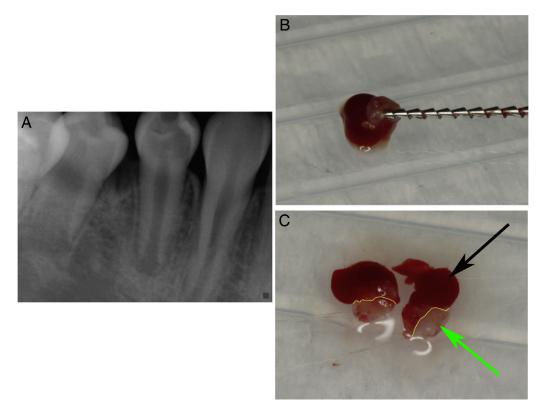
Case report radiograph and clinical photographs. (*A*) A periapical radiograph of tooth #28. (*B*) Periapical tissue was engaged to a H-file after removal from the root canal of tooth #28. (*C*) Tissue was immediately sectioned into 2 pieces, both containing part of the apical papilla (*green arrow*) and part of the inflamed periapical tissue (*black arrow*). The *yellow lines* represent the junction between the 2 distinct tissues.
